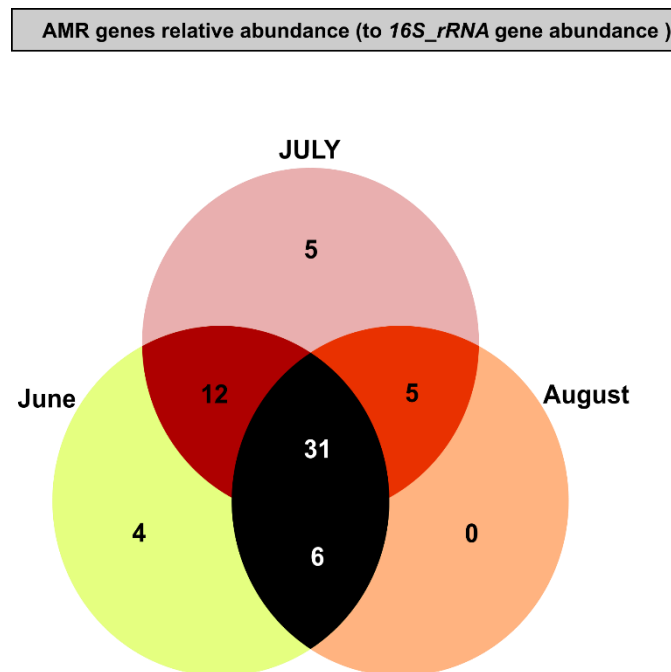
Number of gene with increased abundance (relative to the *16S rRNA* gene) in the effluent from the influent of the CST-Household unit (CT-P3 only) across the three sampling months (June, July, August). A) Number of AMR genes increased in the effluent from influent for all targeted antibiotic genes in the CST-household unit (CT-P3 only) across the three sampling months (June, July, August). B) Number of increased integrase genes (*intI1*, *intI2*, *intI3*) in the effluent from influent for the CST-household unit (CT-P3 only) across the three sampling months (June, July, August).
